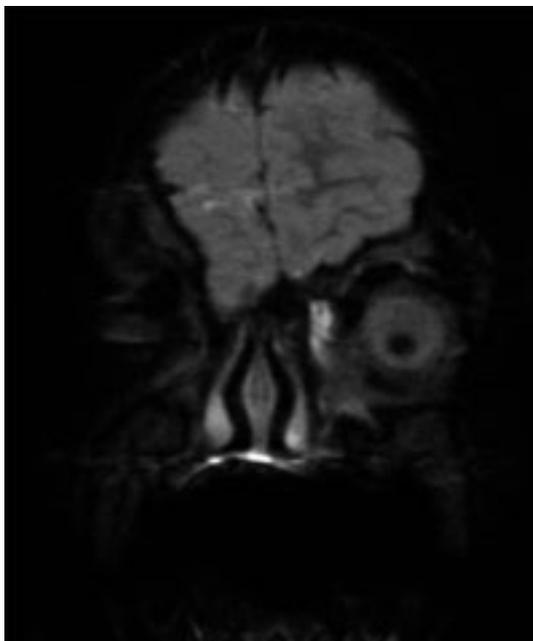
the late phase of the MRI cysternography, showing a leakage of CSF in the nasal periorbital soft tissues of the left eye.
